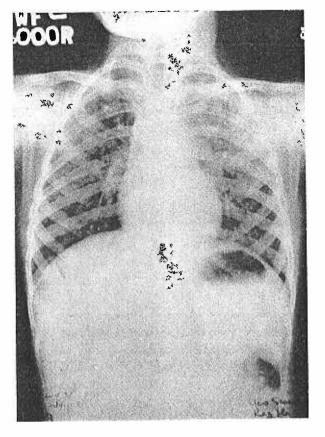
Radiograph of the chest in a case of renal tuberculosis. Note the miliary mottlings of the lung.
